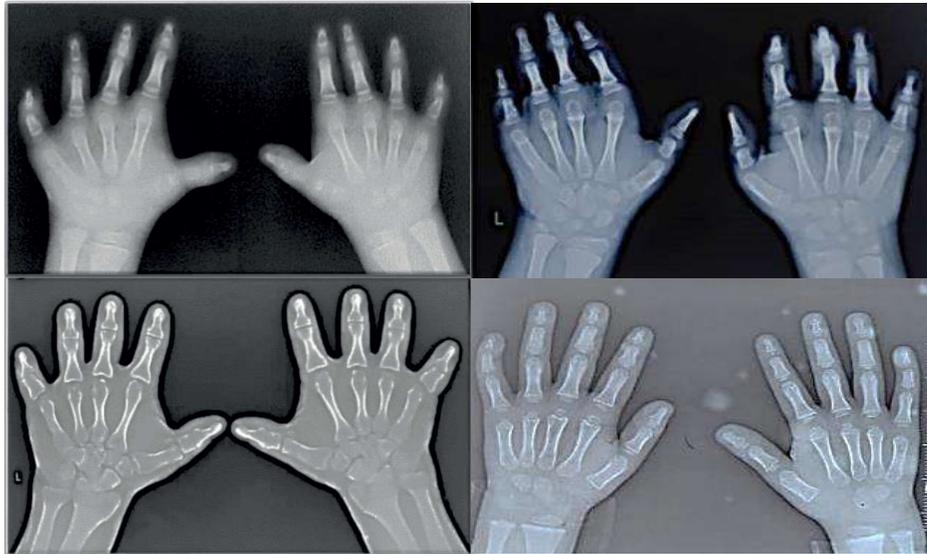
X-ray film of affected individuals of BDA
